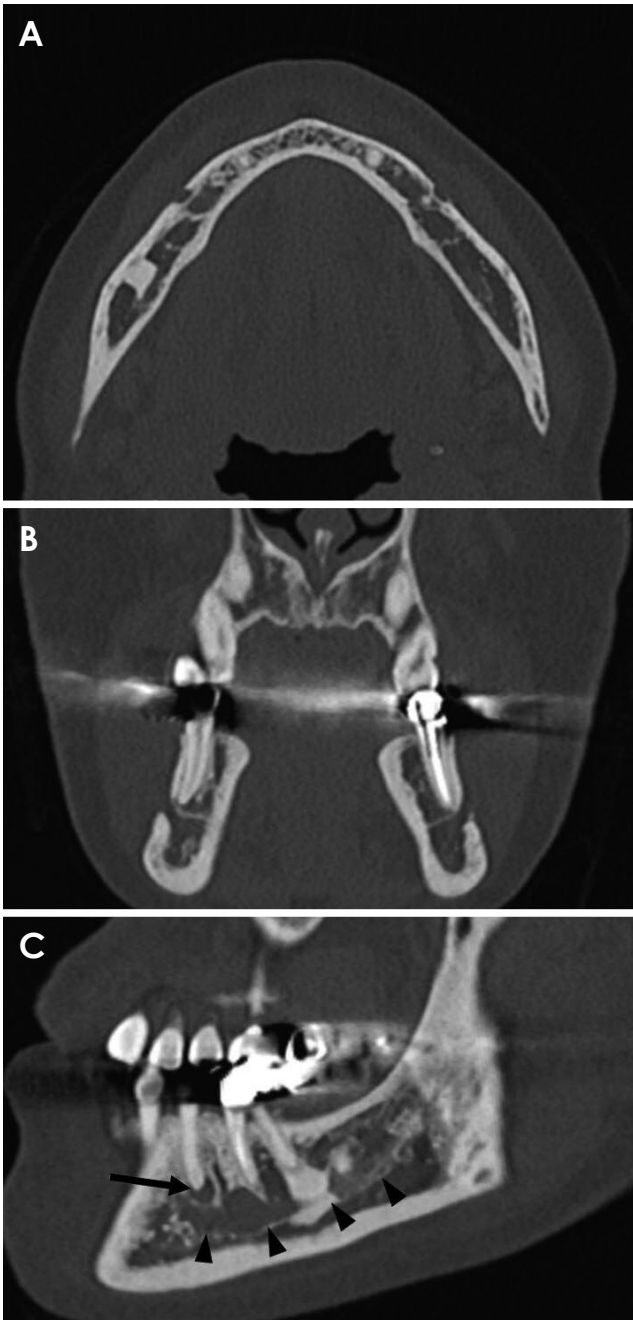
A and B. No apparent pathological bone changes are evident on bone window multislice computed tomography (MSCT) images. C. Parasagittal MSCT image under the bone window setting demonstrates a close relationship between the periapical lesion (indicated by the arrow) and the inferior alveolar canal (indicated by the arrowheads).
